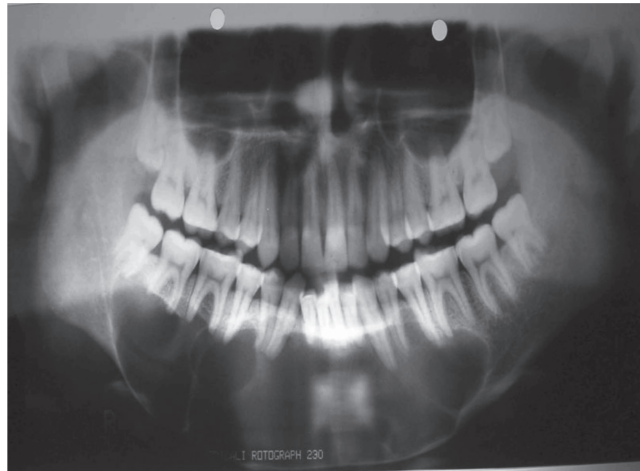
Preoperative orthopantomogram (before extraction) showing multilocular radiolucency in mandible with root resorption.
